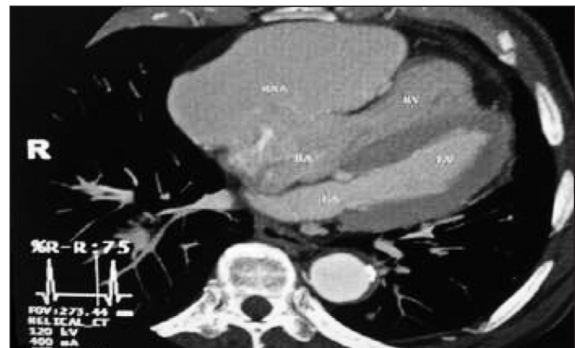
Computed tomography angiography scan demonstrating a right atrial aneurysm. LA; Left atrium, LV; Left ventricle, RA; Right atrium, RV; Right ventricle, RAA; Right atrial aneurysm.
